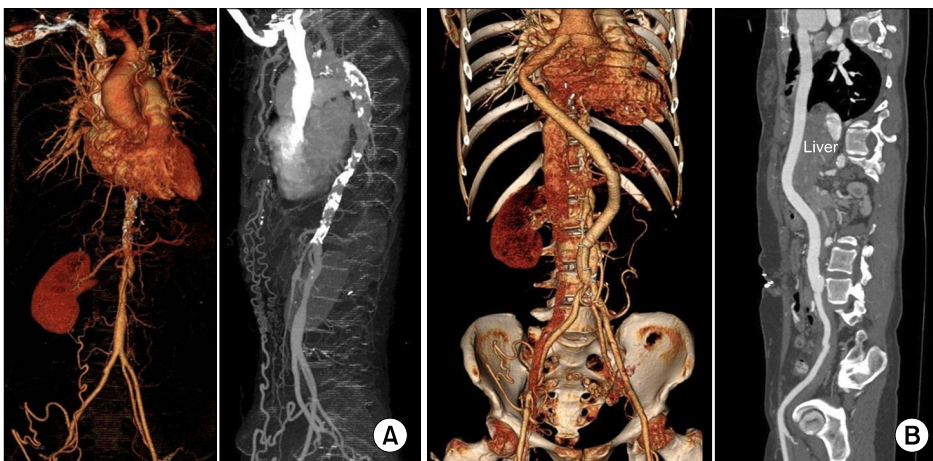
(A) Preoperative computed tomography angiography. It shows diffuse calcification and narrowing of the descending thoracic and abdominal aorta. (B) Postoperative computed tomography angiography.
